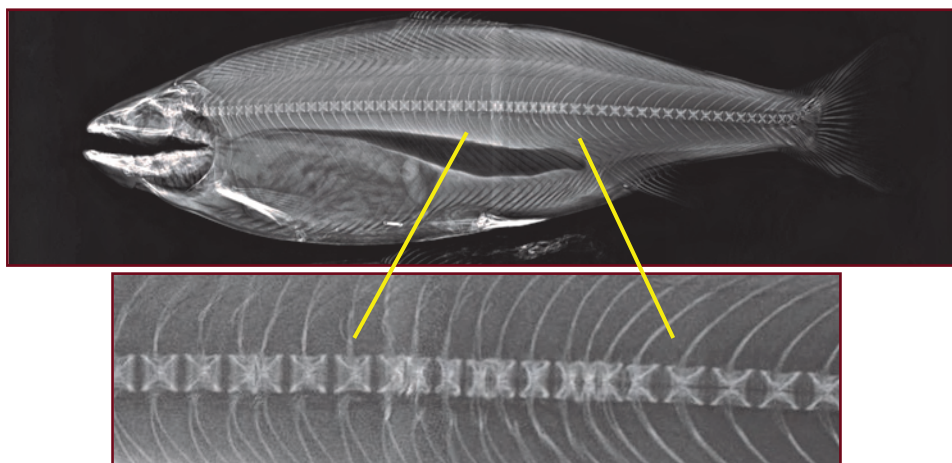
Zn-deficiency induced vertebral pathology in A. salmon. Exposure to deficient diet from first feeding to 30g size. X-ray at 2 kg, following 8 months in seawater on commercial diet.
